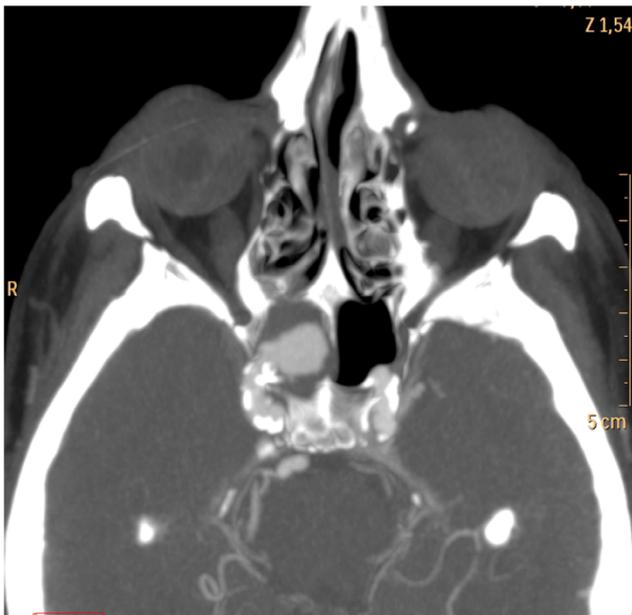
CT-angio showing right carotid siphon aneurysm, located in the sphenoid sinus
